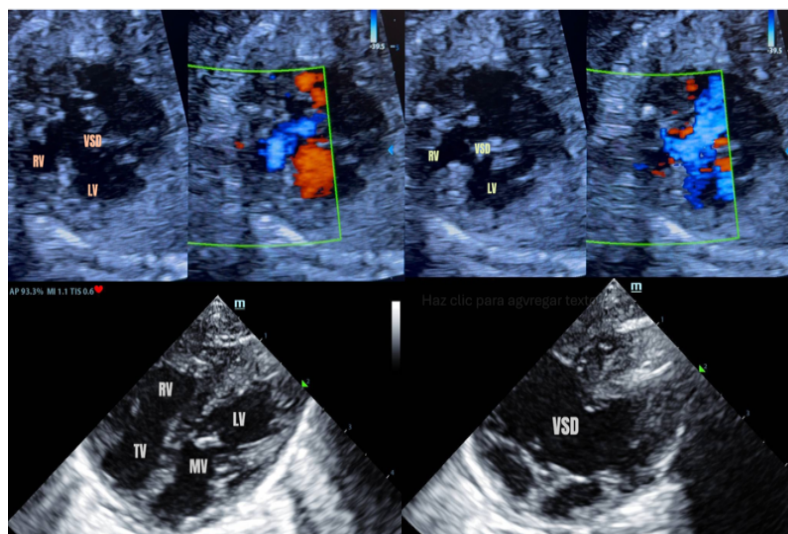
Prenatal (23 weeks) and postnatal Echocardiograms whit a large ventricular Septal Defect
